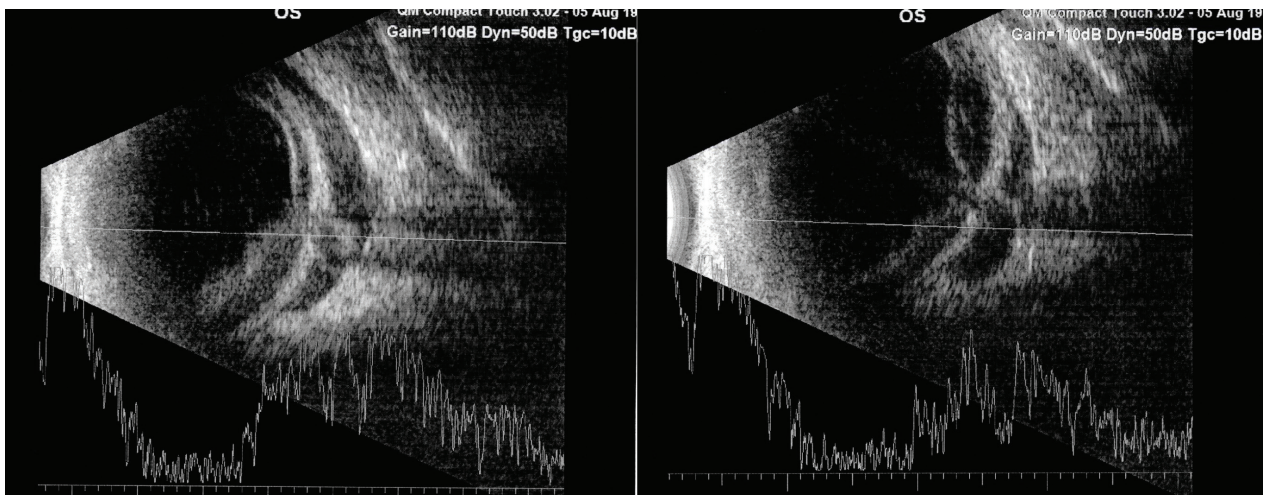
Ultrasonographic examination of the left eye: retinal and choroidal detachment, optic nerve disc overlapped by the tumour, negative echo at 5mm depth
